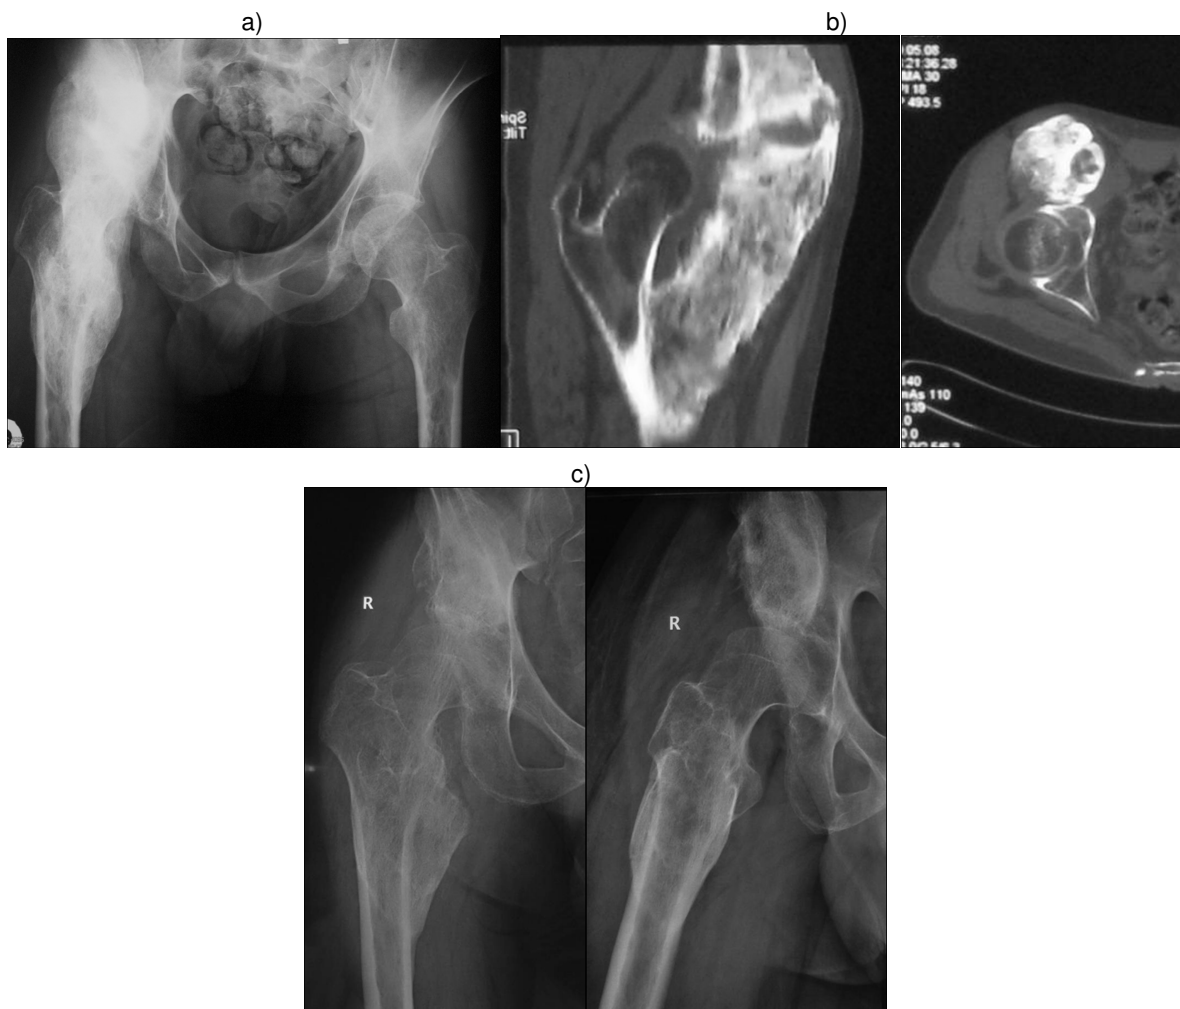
Heterotopic ossification in the right hip causing severe ankylosis. a) Preoperative imaging showing a huge HO from the lesser trochanter to the ilium. b) Preoperative CT-Scan showing involvement of the muscles iliopsoas, vastus medialis and vastus intermedius. c) Radiograph 12 months after surgery.
